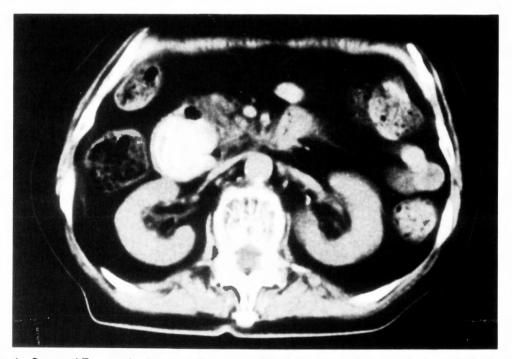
Computed Tomography showed a 4.0×4.0 cm round calcified mass in the second portion of the duodenum.
